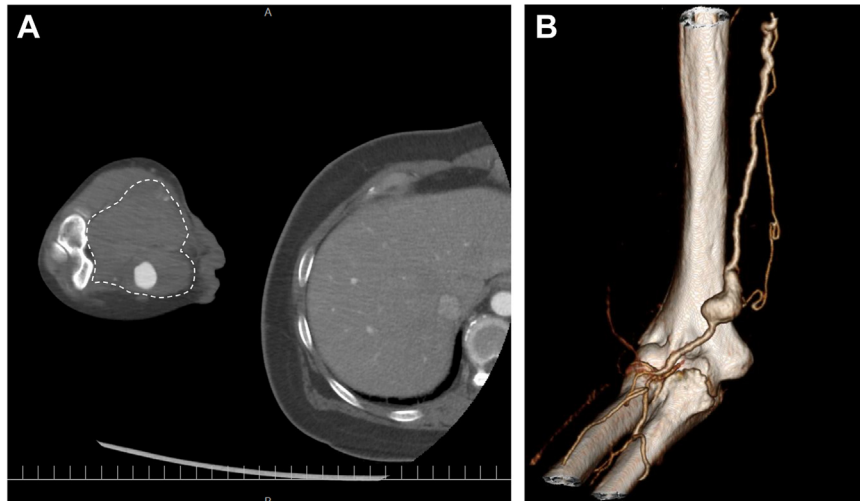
Contrast-enhanced dynamic computed tomography (CT) views revealing a spindle aneurysm (size, 17 mm) in the right brachial artery. Dotted line represents the surrounding hematoma.
